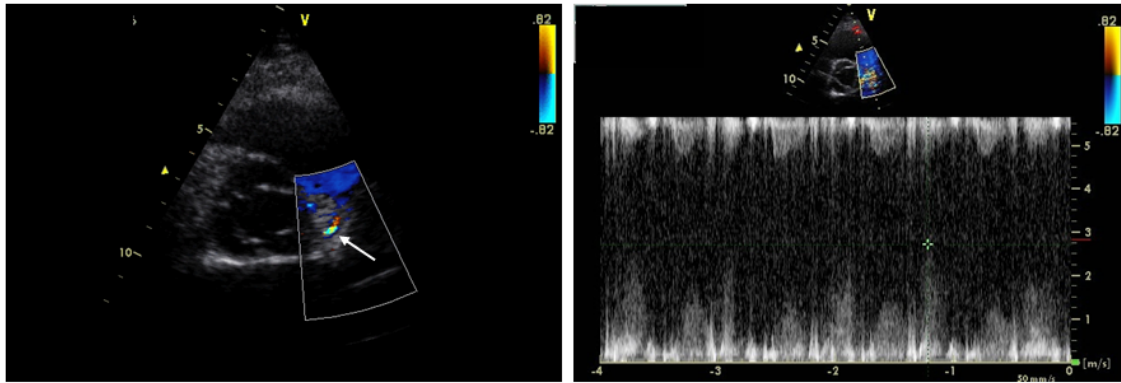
During TTE with pulsed-Doppler measurements (Toshiba Powervision 8000, Tokyo, Japan), significant increase in coronary flow velocities in distal LM after appropriate angle correction could be demonstrated.
